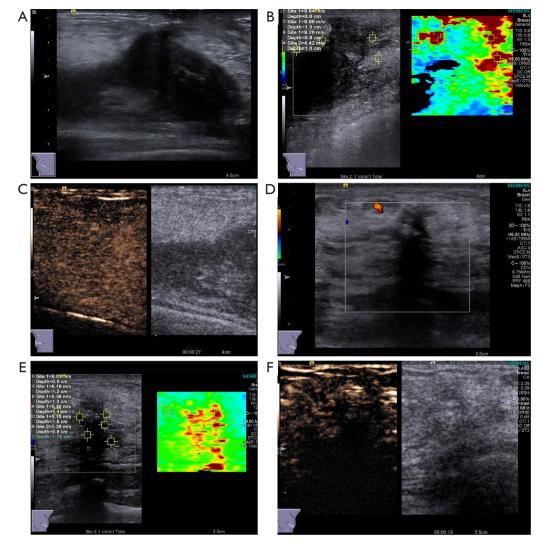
Ultrasound images of desmoid-type fibromatosis of the breast. Case 2: (A) conventional grayscale ultrasound showed a hypoechoic mass close to the muscle layer in the right breast. (B) Shear wave elastography demonstrated higher hardness of the larger mass. (C) Contrast-enhanced ultrasound revealed heterogenous enhancement in the mass. Case 3: (D) power Doppler flow imaging displayed sparse blood flow signals within the mass in the left breast. (E) Shear wave elastography demonstrated moderate hardness of the mass. (F) Contrast-enhanced ultrasound image revealed heterogenous enhancement in the mass.
